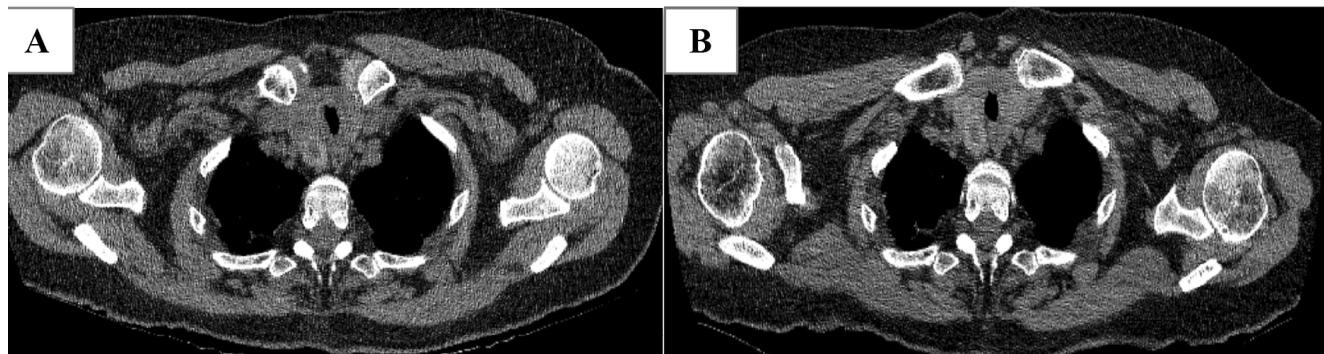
A) Computed Tomography (CT) scan of July 2023. B) CT scan of October 2023 after treatment with ICS/LABA for one month. ICS, Inhaled Corticosteroids; LABA, Long-Acting Beta-2-Agonist.
